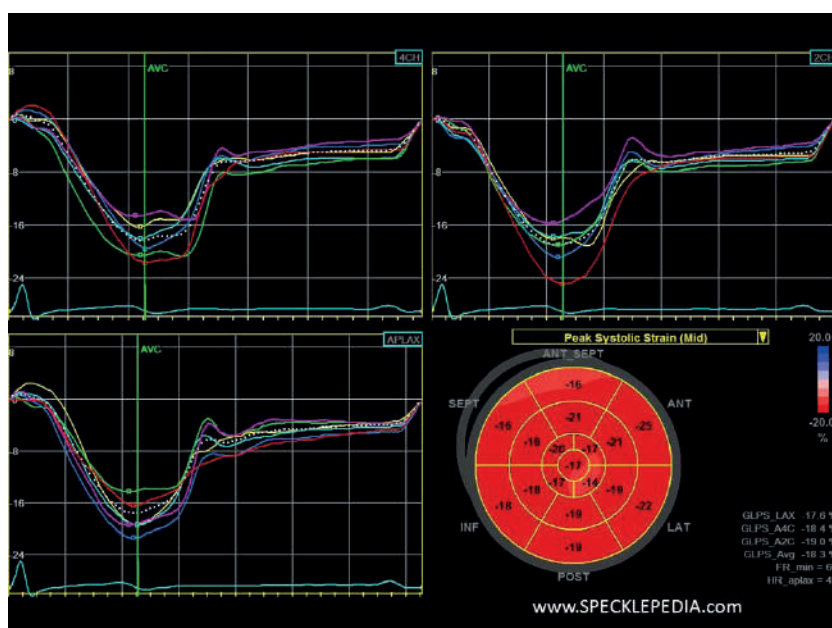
Speckle tracking echocardiography. Indicators in a healthy person. Indicators of global longitudinal strain (GLS) in different segments of the myocardial section vary from -16 to -22, which corresponds to normal values [25].
